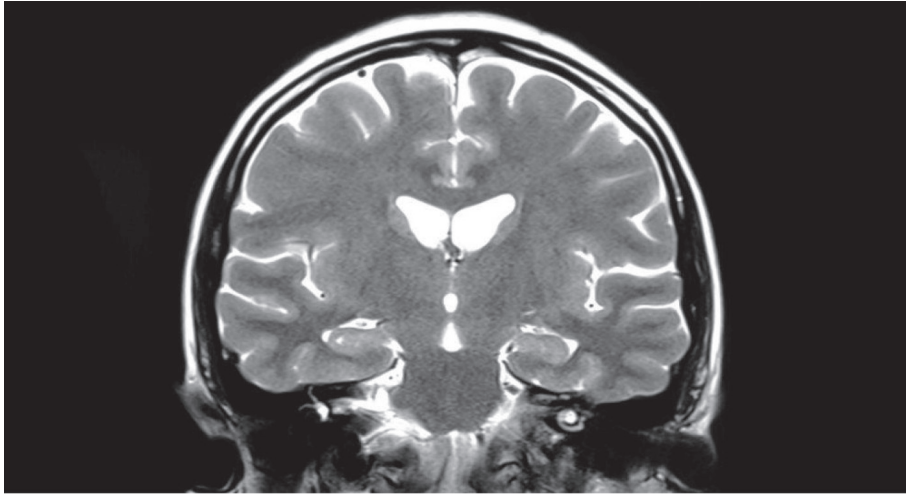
Example of magnetic resonance imaging (MRI).
